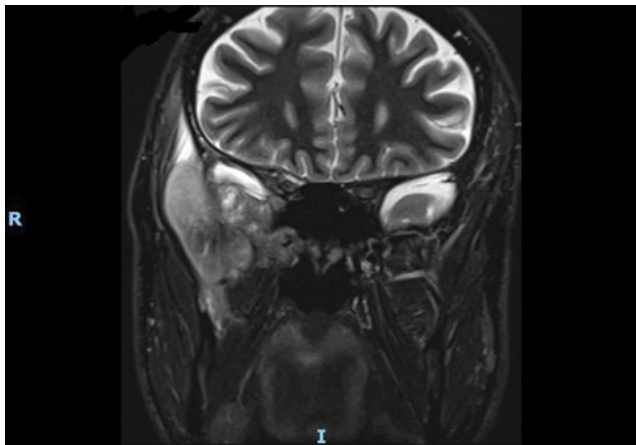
MRI pre-operative coronal T2 image.
